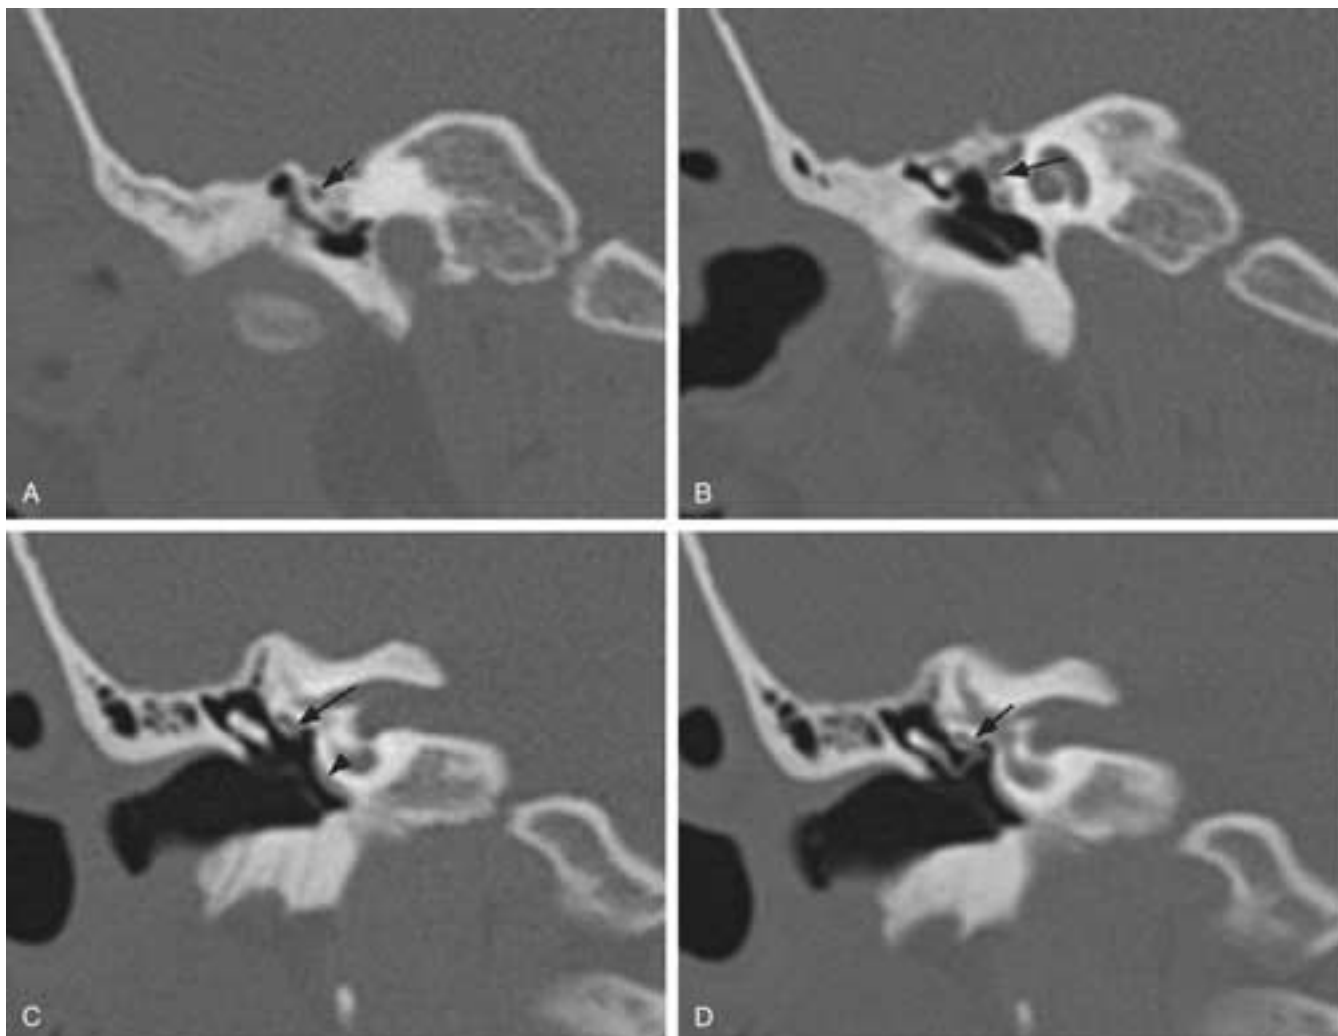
PSA. A to D, Coronal CT images from anterior to posterior. The narrow presumed vascular structure is seen at level C (*arrowhead*), coursing along the promontory. At level D, the small vascular structure crosses the oval window niche, to end in the lower inferomedial aspect of the tympanic segment of the facial nerve canal (*arrow*). This small channel is also seen at level C (*arrow*). More anteriorly (A and B), the small canal (*arrows*) courses just inferior to the tympanic segment of the facial nerve canal in a separate channel as it passes toward the floor of the middle cranial fossa. The small soft-tissue structure immediately inferior to this canal is the tensor tympani muscle within its semicanal.
